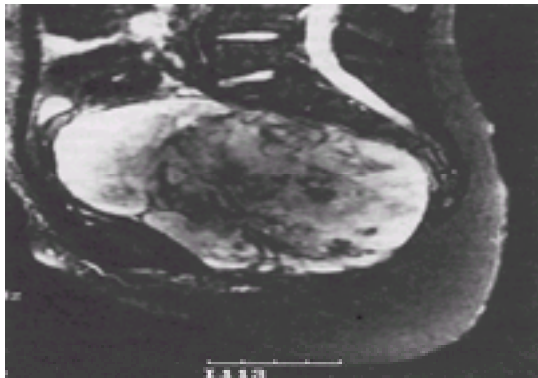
MRI scan of an 8-year-old girl who presented with months of constipation and then acute urinary retention. A large pelvis mass was shown to be an immature sacrococcygeal teratoma (type IV).
